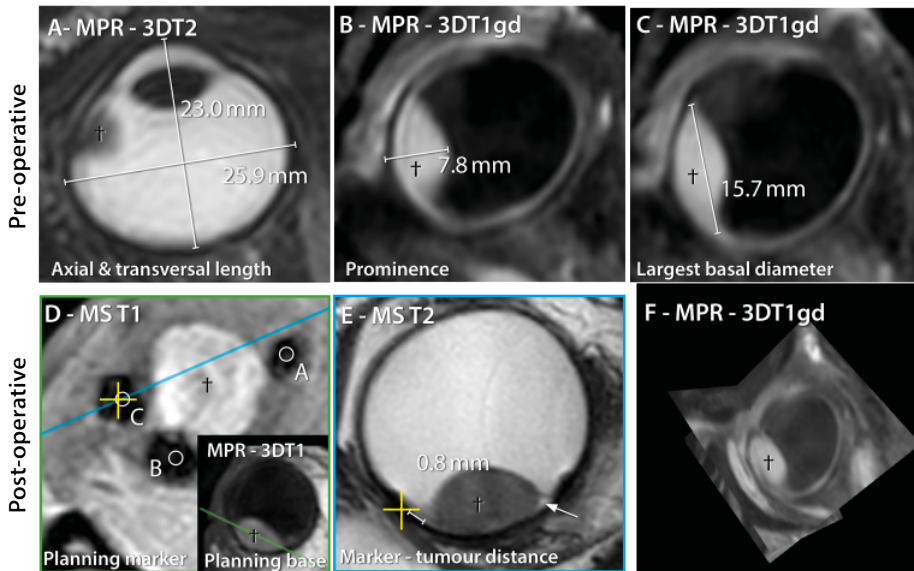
Primary pre- and post-operative MRI based measurements. (A) The axial length and transversal length were measured on a multi planar reconstruction (MPR) of the 3DT2. (B,C) The prominence, including sclera, and largest basal diameter were measured on a MPR of the 3DT1gd. (D) A multislice T1 scan was acquired through the base of the tumor (dagger). Subsequent scans per marker (T2 (E) and T1) were acquired perpendicular to this plane through the center of the tumor and marker. (E) Multislice T2 used to measure the distance between tumor and marker. Note the small retinal detachment adjacent to the UM (arrow) (F) 3D volumes as acquired with MRI allow for multi planar reconstructions (MPR) in all directions providing the opportunity to accurately determine the largest basal diameter, prominence and visualize the relation between tumor and surrounding tissue.
